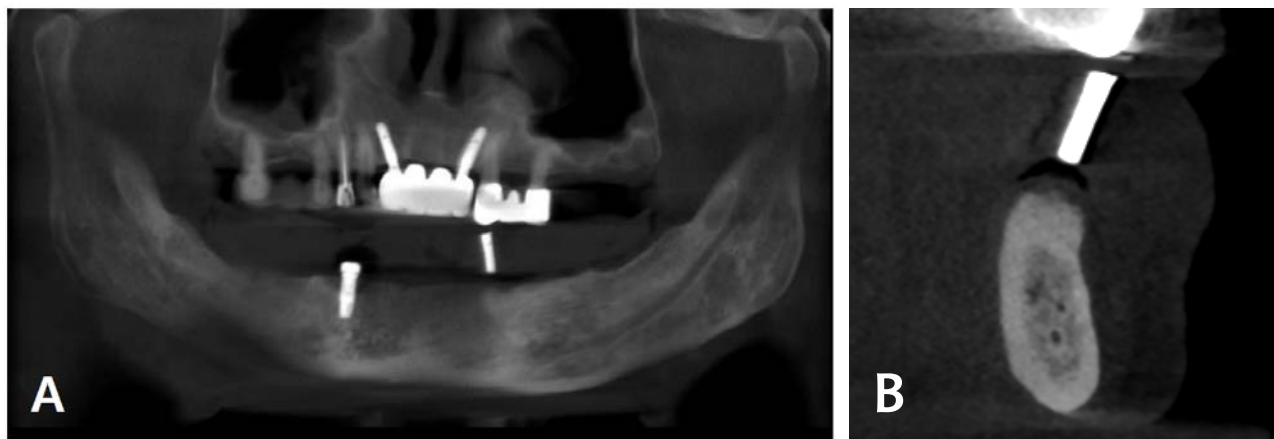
CBCT image at 2 months later of #33 implant removal and ARP. (A) Panoramic view. (B) Paraxial view.
